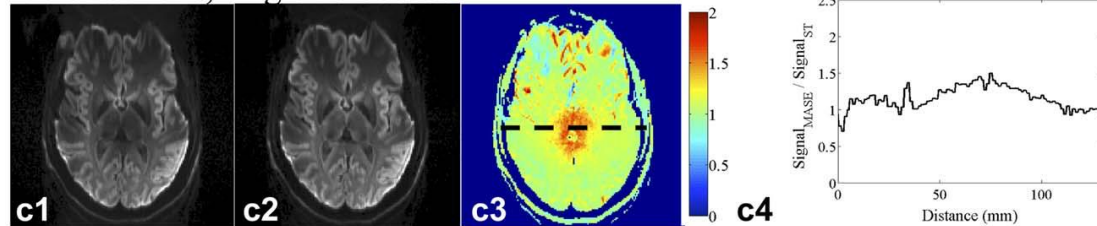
(From (Dyvorne et al., 2016)) Improvements in homogeneity of DWI images acquired at 7T when using adiabatic refocusing pulses. A1,B1,C1 – conventional refocusing pulses. A2,B2,C2 adiabatic refocusing (MASE for single-refocusing, TRASE for double-refocusing). A3,B3,C3 Relative signal adiabatic vs conventional. A4,B4,C4 – Profiles through center of A3,B3,C3.
